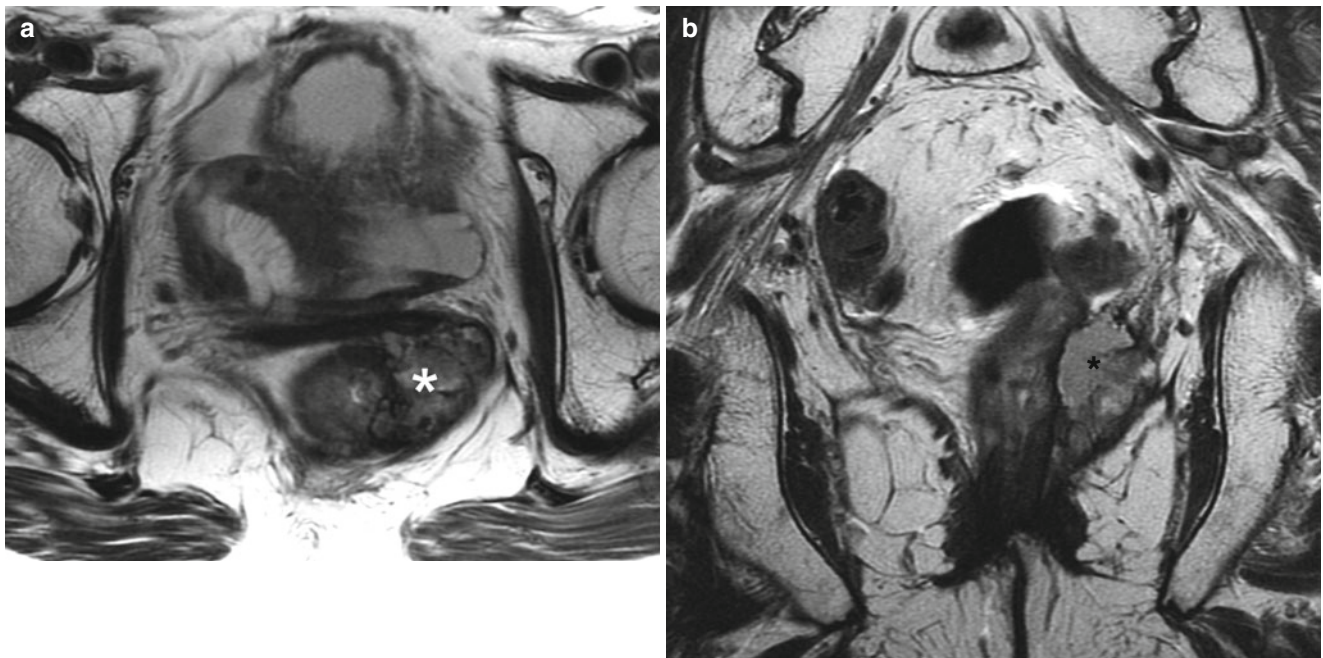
This 72-year-old woman had a history of endometrioid endometrial adenocarcinoma treated with radical hysterectomy, bilateral salpingo-oophorectomy, and adjuvant chemotherapy 10 years earlier. Axial (a), coronal (b), and sagittal (c) T2-weighted MR images and an axial, fat-suppressed T1-weighted image following intravenous gadolinium (d) demonstrate a partially necrotic left pelvic tumor
